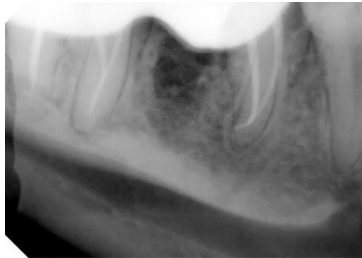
radiograph after 6 months showing complete healing
